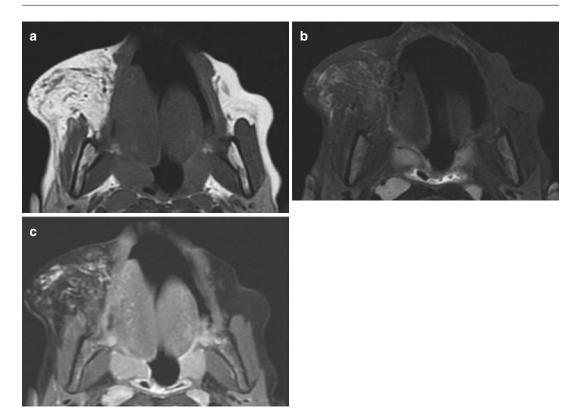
Infantile haemangioma of the cheek in a 7-yearold girl during involution phase. (a) Axial T1-weighted MR image. (b) Axial T2-weighted MR image with fat suppression. (c) Axial T1-weighted MR image after Gadolinium
